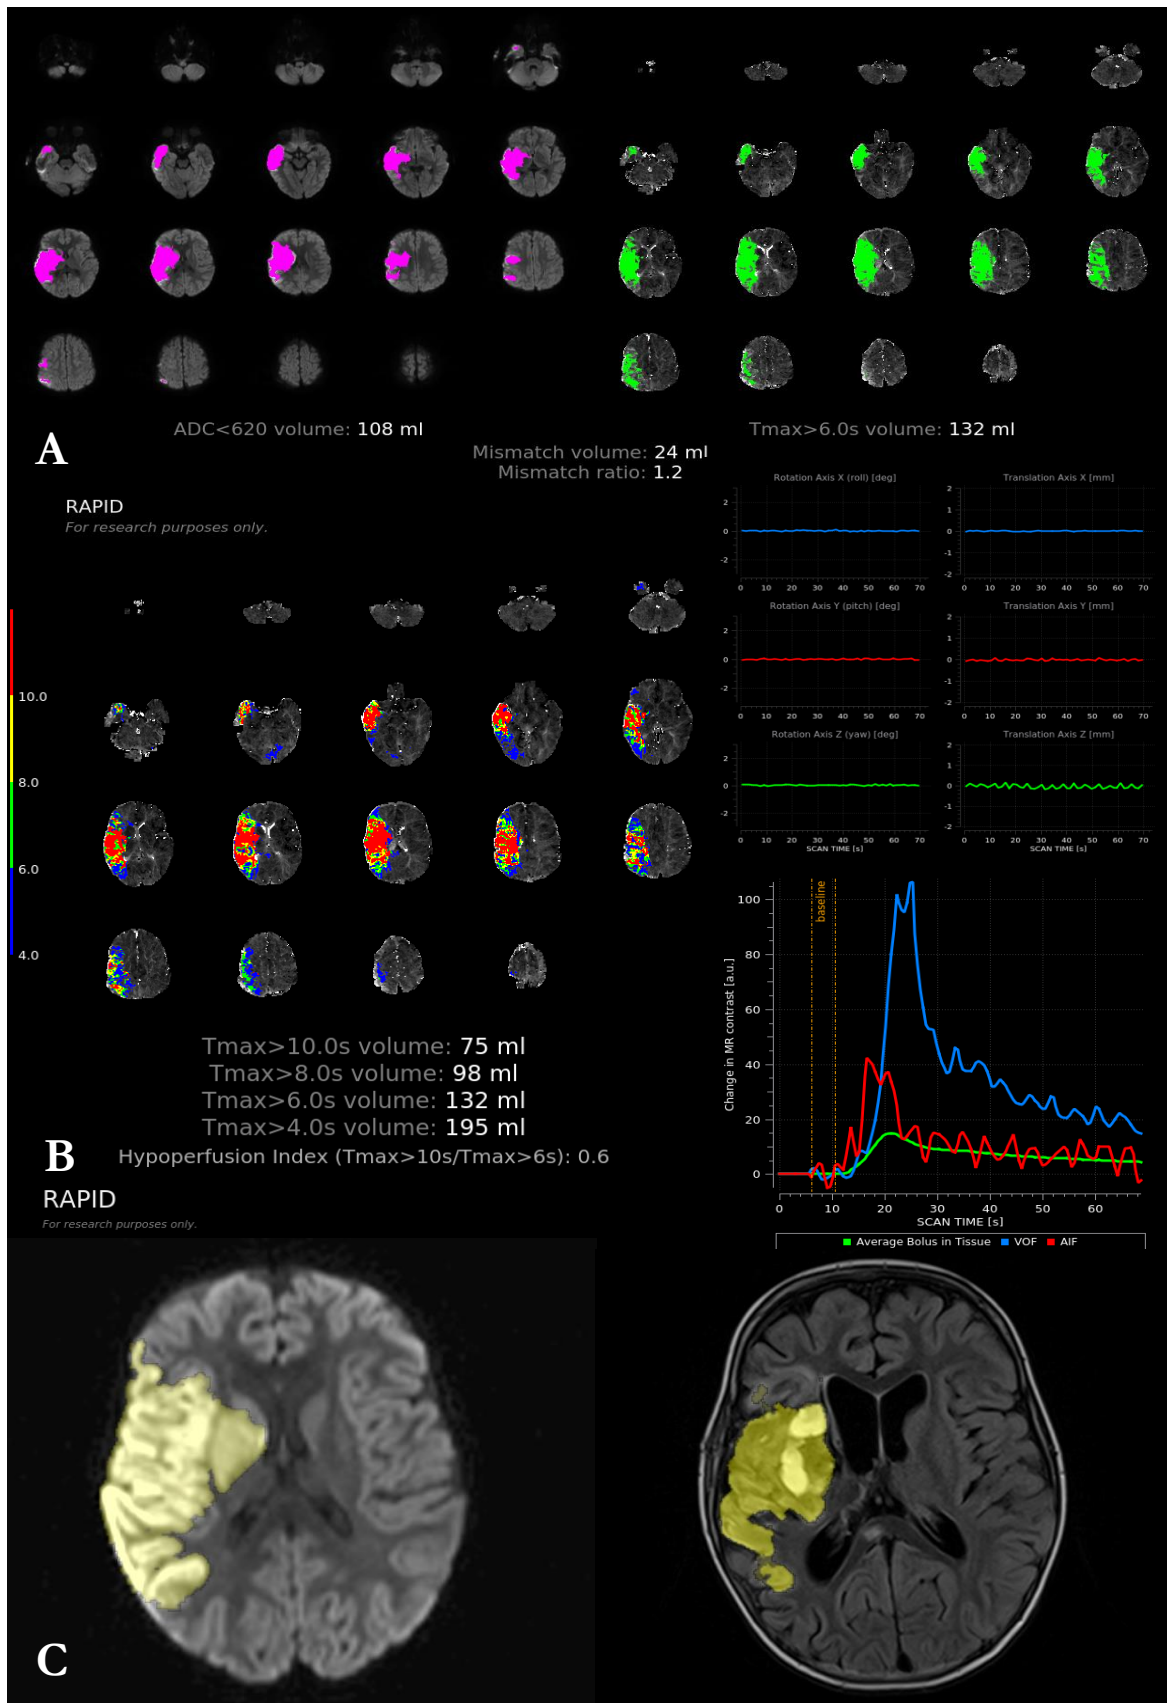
RAPID output and manual segmentation Case study 4 (A) Automated mismatch segmentation core (left) hypoperfusion (right) using standard RAPID thresholds (B) Alternate  $T_{max}$  thresholds, head motion, and AIF curves. (C) Manual segmentation of acute DWI lesion 103.3mls (left) and chronic T2 FLAIR lesion 105.1mls (right)
